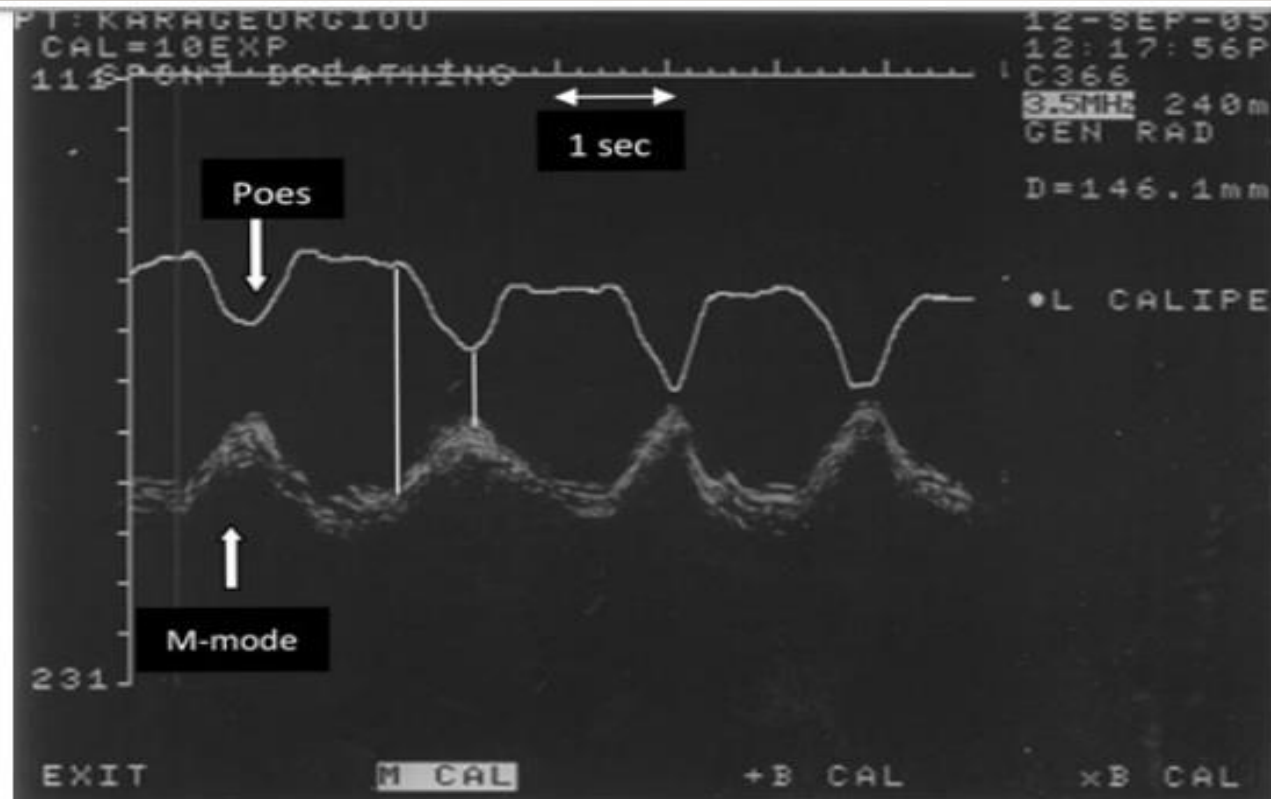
Simultaneous recording of the esophageal pressure and M-mode diaphragmatic sonography. Notice the perfect synchronization of the beginning of diaphragmatic contraction and the drop of the esophageal pressure (*first vertical line*). The *second vertical line* indicates the end of inspiration and the maximal pressure drop in the esophageal pressure
